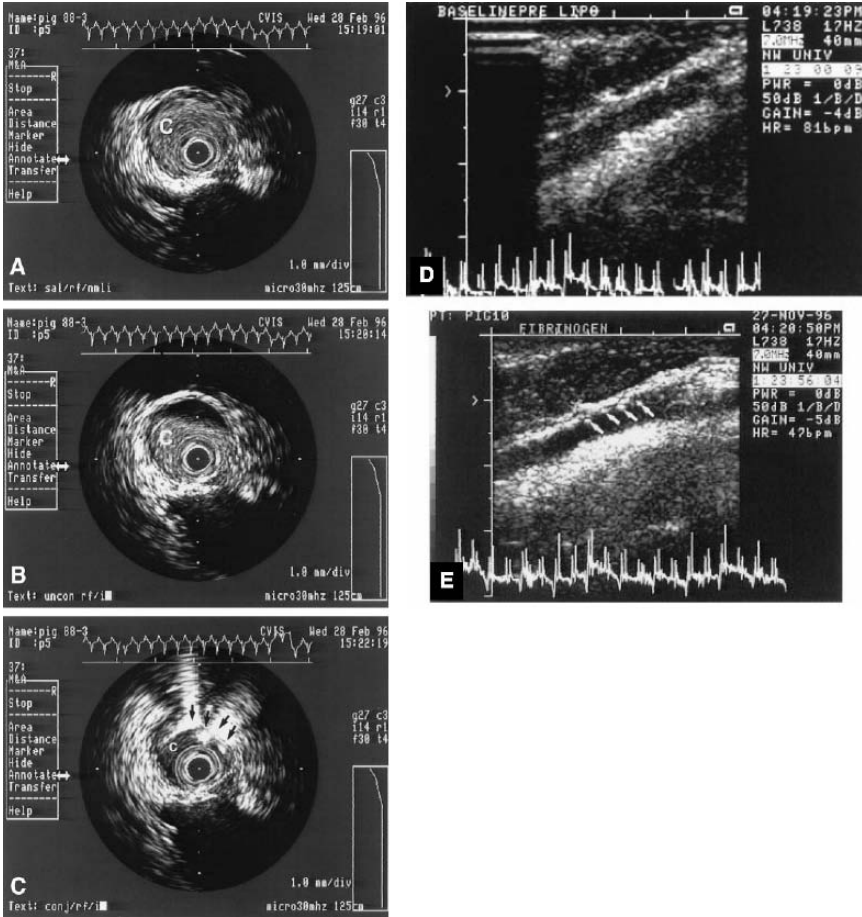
In vivo enhancement of complex atheroma by anti-fibrinogen-conjugated echogenic immunoliposomes. Intravascular ultrasound images of the right femoral artery of a Yucatan miniswine with a large central thrombus. A After injection of saline. B After injection of unconjugated liposomes. C After injection of antifibrinogen-labeled liposomes. (The dark central area is catheter imaging artifact. C = intraluminal thrombus/clot; arrows point to liposomes attached to thrombus.) Transvascular ultrasound images of an atherosclerotic left carotid artery of a Yucatan miniswine (D) after injection of saline and (E) after injection of anti-fibrinogen-labeled liposomes (arrows point to liposomal attachment to fibrinogen in the atherosclerotic plaque). Reproduced with permission from Demos et al. (1999).
